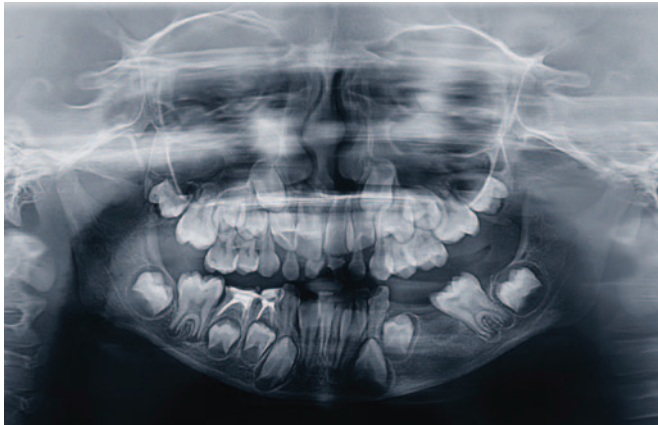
Six-month follow-up orthopantomogram.
